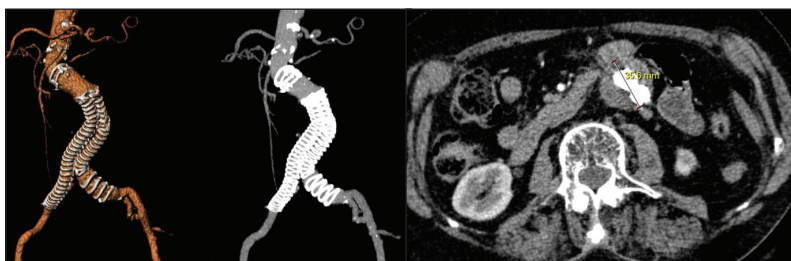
CTA at 5 years.
